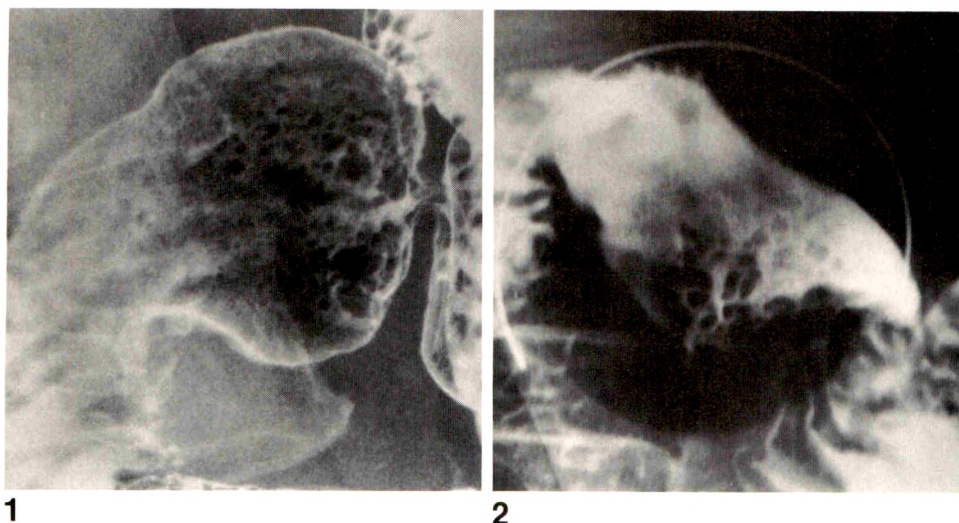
Air-contrast radiograph (obtained with patient in supine position) shows multiple abruptly margined excrescences of different size in the duodenal cap, characteristic of heterotopic gastric mucosa. Endoscopy was not performed.
